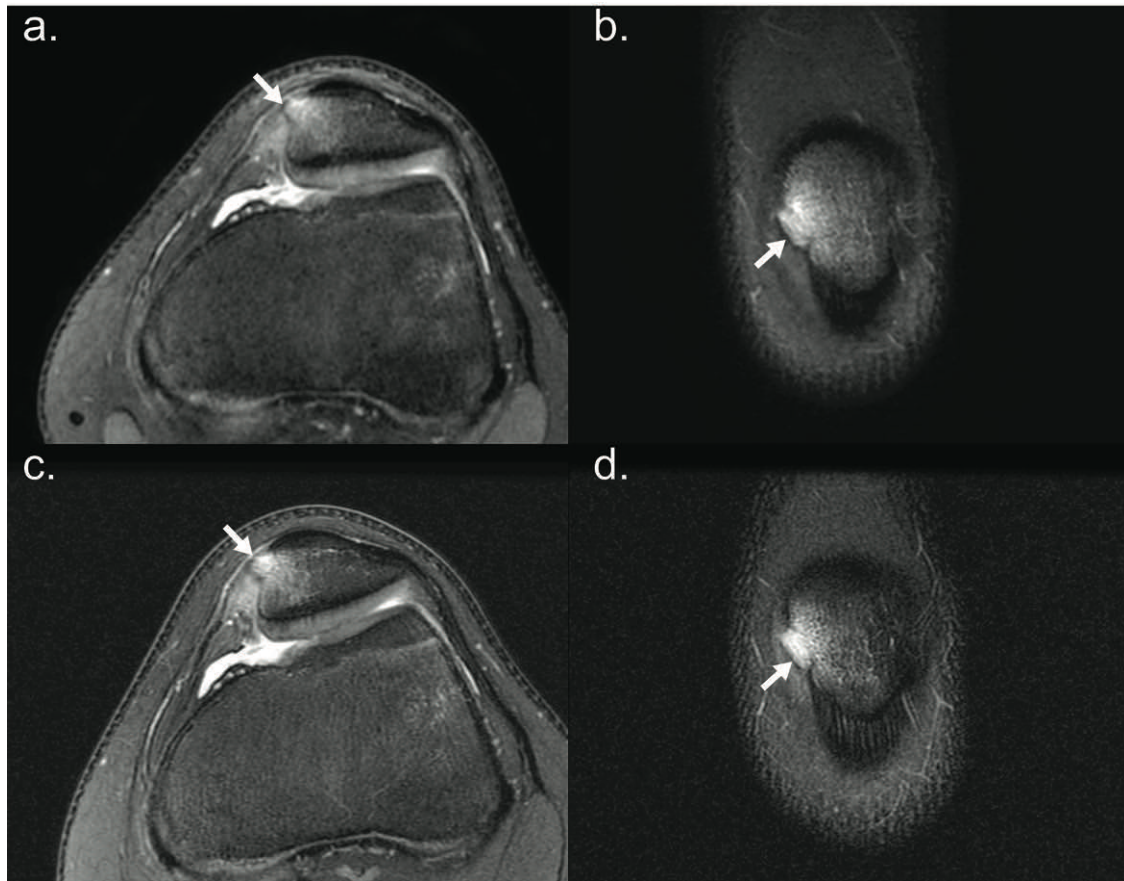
A 15-year-old boy with medial retinaculum avulsion. (a) T2 Shuffling proton density (PD) axial reformatted and (b) T2 Shuffling T2-weighted (T2W) coronal reformatted MR images of the knee show a medial retinaculum avulsion and adjacent bone marrow edema (arrows) with similar delineation compared to (c) conventional 2D fast spin-echo (FSE) fat-suppressed (FS) PD axial and (d) FS T2W coronal images.
